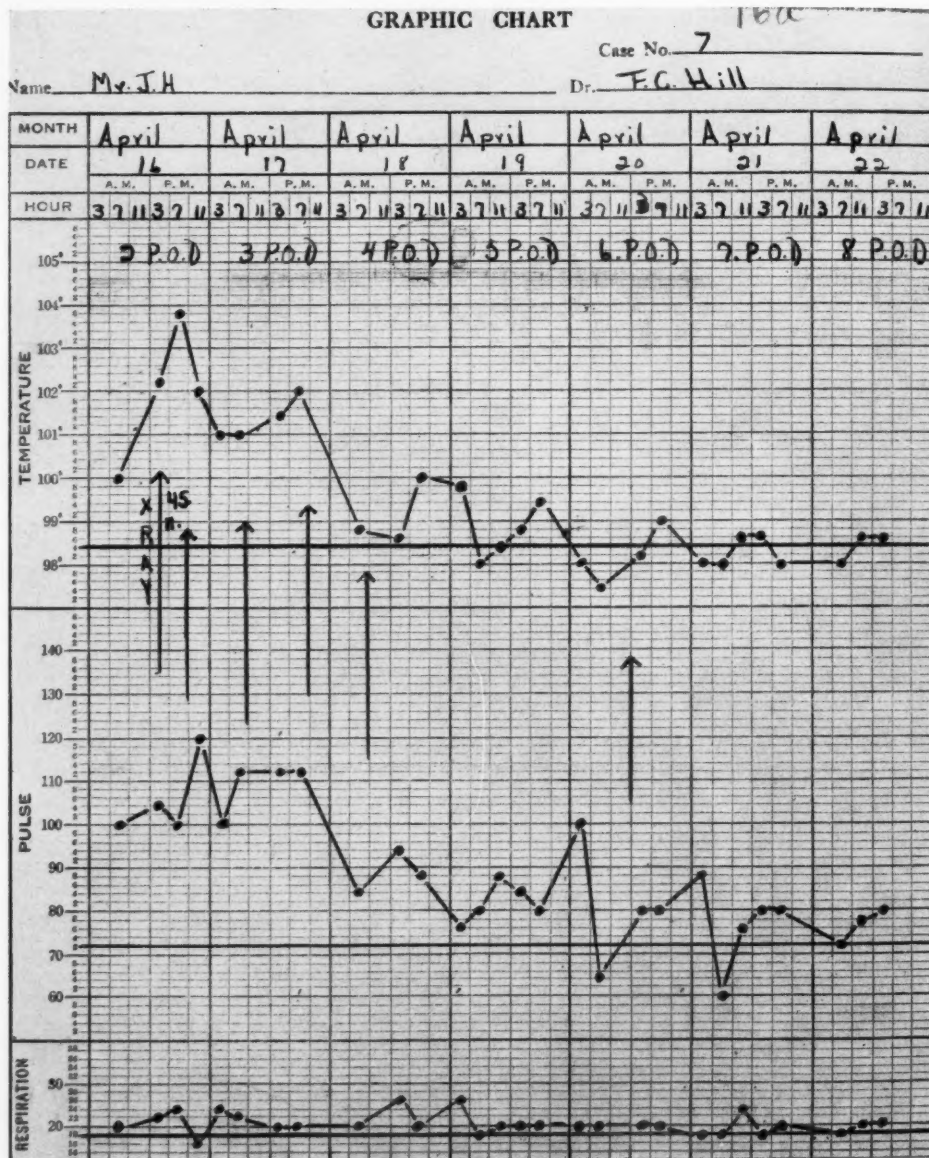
Case 7. Diagnosis: surgical parotitis. X-ray technic: kv. 110; ma. 5; distance 50 cm.; filter 3 mm. Al; r units, 45 for three treatments and 60 for three treatments, total 315; port, both parotid glands; result, excellent.
